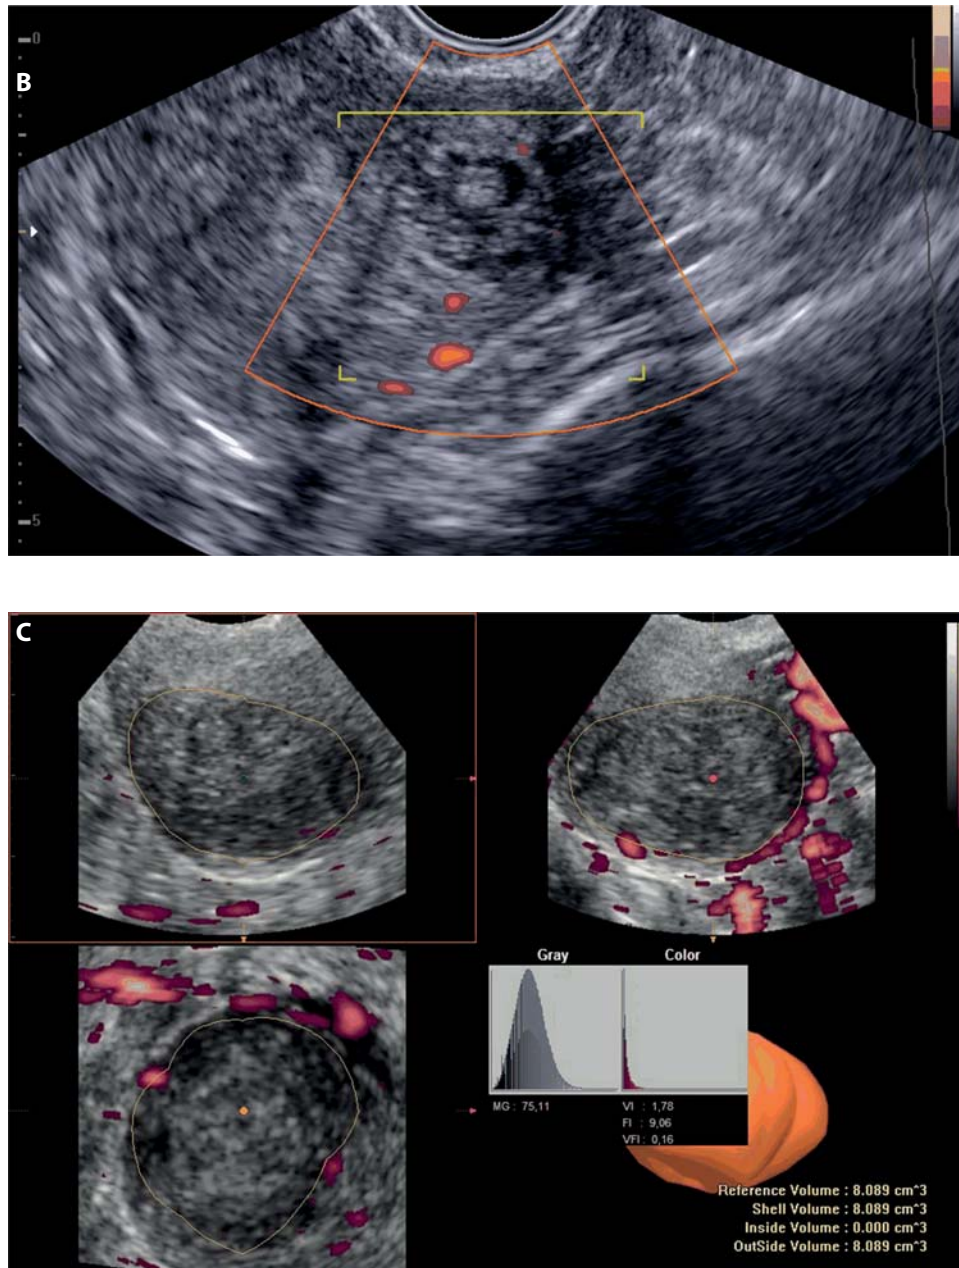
Three dimensional Power Doppler ultrasound (3D PD US) of a fibroid
